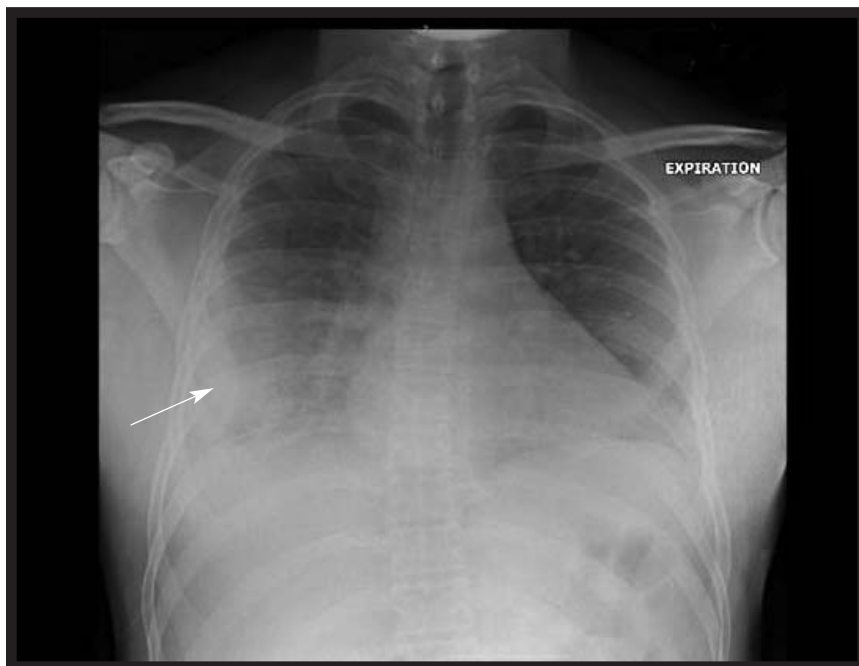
A right pleural effusion is seen on the patient's radiograph.
